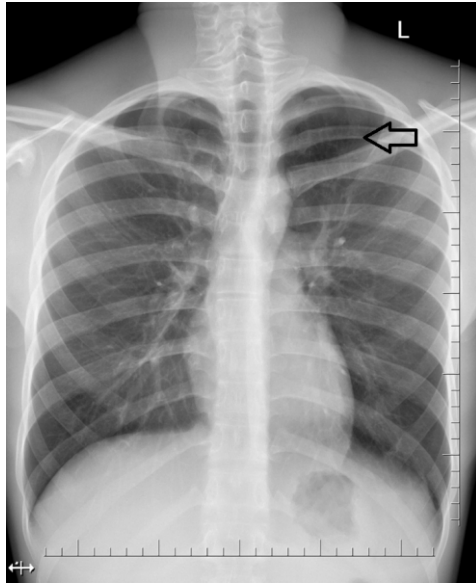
Chest X-ray showing a short rib on the left side. The anterior end is marked with an arrow.
